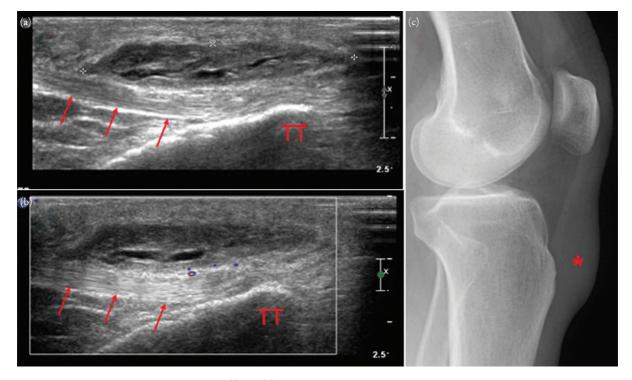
Superficial infrapatellar bursitis. Panels (a) and (b), respectively, show gray scale and color Doppler images in longitudinal plane of the anterior inferior knee with a subcutaneous soft tissue mass superficial to the distal patellar tendon (arrows = patellar tendon). The mass has no internal flow. Companion plain radiograph of the knee (Panel (c)) shows focal soft tissue swelling in the region of the superficial infrapatellar bursa (*) anterior to the tibial tuberosity.
